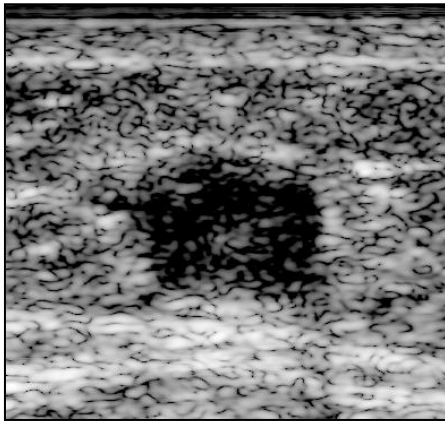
Ultrasound image of the vein with DVT (dark, hypoechoic region in the center). Based on the geometry, the blood clot, vessel and the surrounding tissue can be described using a cylindrically symmetric model where the elastic modulus varies along the radial position from the arbitrary center of origin.
